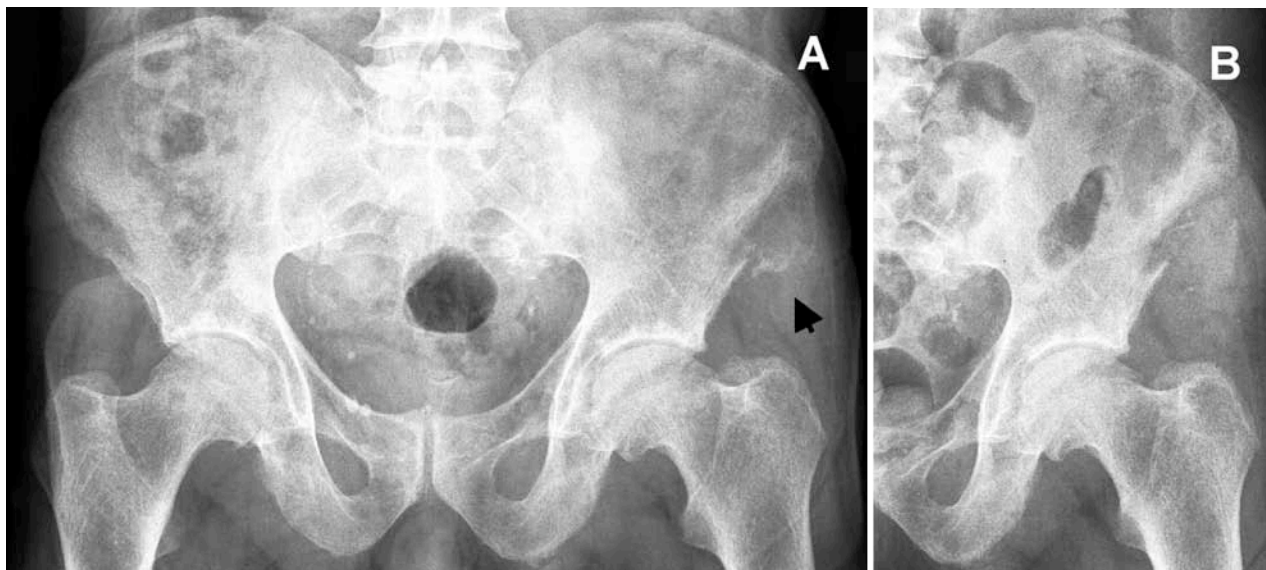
Brown tumor lesion at the left iliacal crest in refractory primary hyperparathyroidism. Preoperative plan radiographic survey of the pelvis (A) measuring about 4.0 x 3.0 cm, bony distension and interruption of the cortical substance (arrow). Please note a small asymptomatic brown tumor lesion at the right sided femoral neck. Plan radiography of the left sided pelvis after complete curettage of the brown tumor lesion (B).
